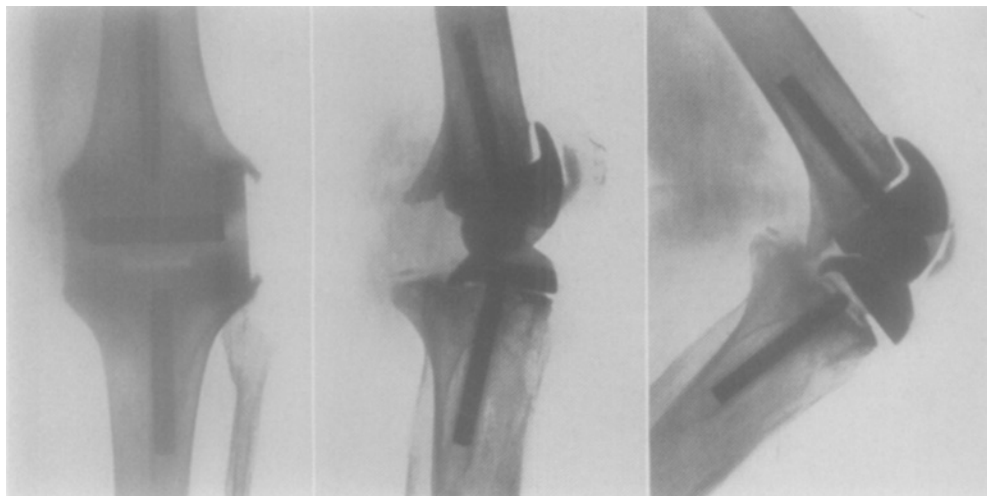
Case 23: roentgenograms of left knee 1 year 4 months after arthroplasty.
